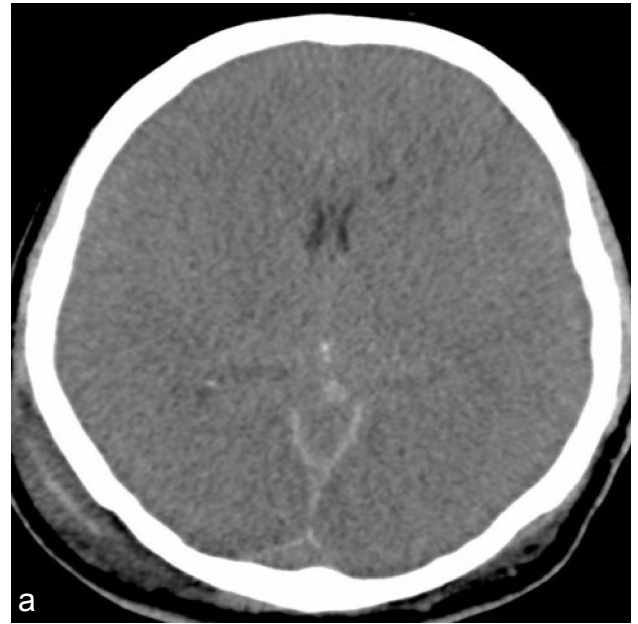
a & b: CT scan Axial & Sagittal Brain Image: Diffuse hypodensity is seen involving the cerebral hemispheres bilaterally with loss of gray white matter differentiation (Reversal sign). There is apparent high attenuation of cerebellum and brainstem relative to cerebral hemispheres (White cerebellum sign). Findings represent Global cerebral ischemia
